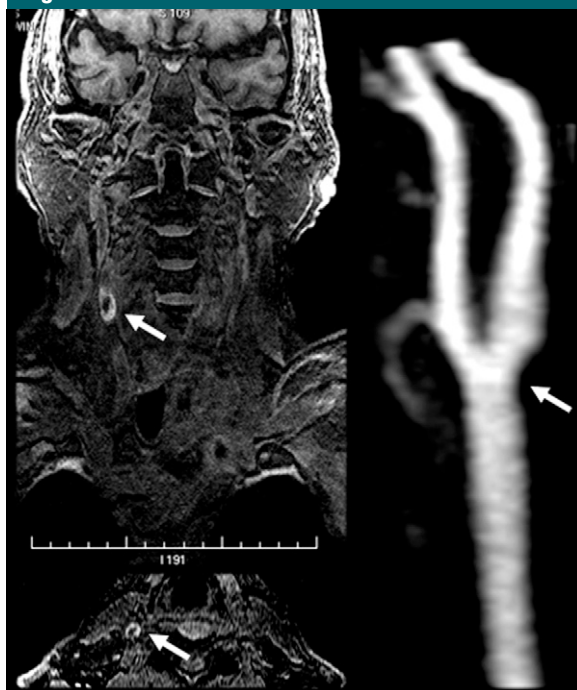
(Top left) Coronal and (bottom left) axial MR images depicting IPH in 83-year-old man show high signal intensity in the right carotid artery (arrows). Right: MR angiogram of right carotid artery (arrow) in same patient.
